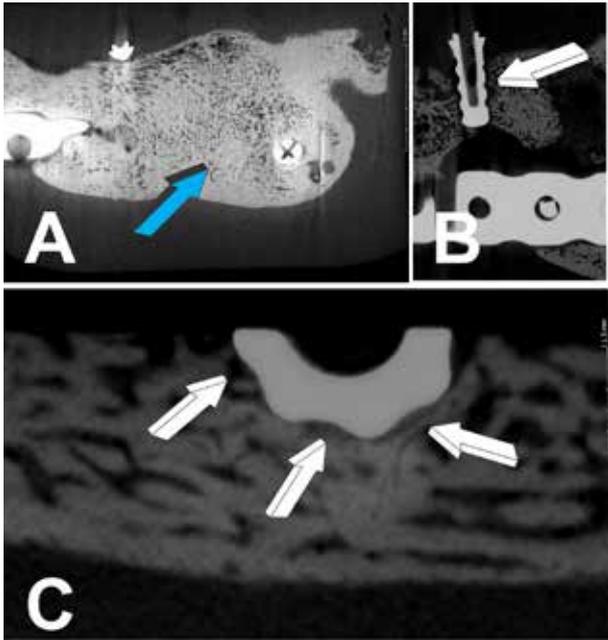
Series of generated μ CT scans 9 months after implantation of the 250 μ g hTGF- β_3 osteogenic device per gram of human demineralized bone matrix (hDBM) with mineralization of the construct. A. Regeneration of bone across the 3 cm mandibular defect (light blue arrow). B. μ CT scan on day 15 after implantation of the geometric titanium construct showing lack of bone induction within the concavities (white arrow) of the analysed implant. C. Transversal μ CT scan indicating the lack of bone formation within the concavities of the geometric implant (white arrows) 15 days after implantation into the regenerated mandibular bone.
